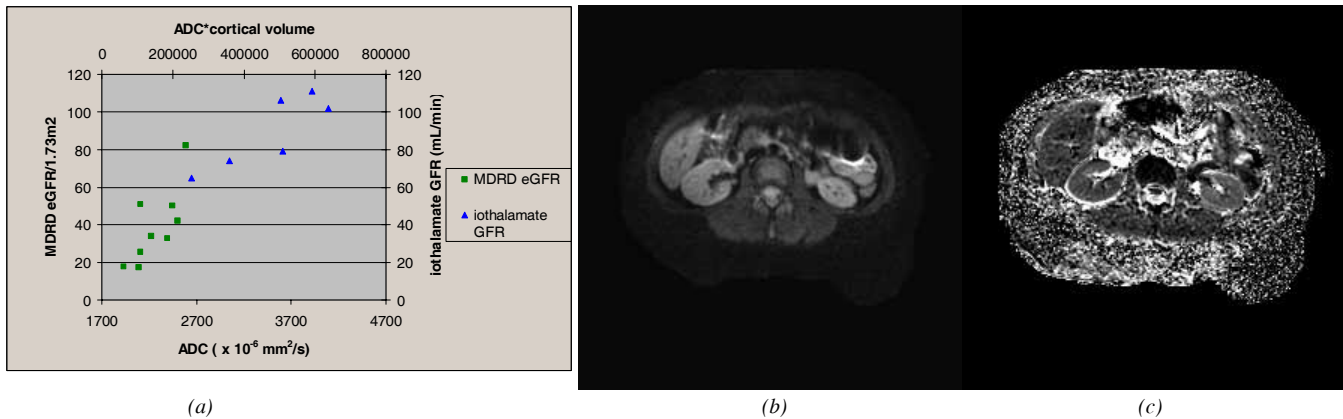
(a) GFR vs. renal ADC. Green squares represent hospital subjects with chronic kidney disease. In these patients no post-contrast images were available and GFR was estimated from the MDRD equation. Blue triangles represent transplant donors or potential donors. In these subjects GFR was measured directly, and cortical volume was also measured using post-contrast MRI. (b) diffusion-weighted image in a transplant donor candidate (c) ADC map from the same image.
